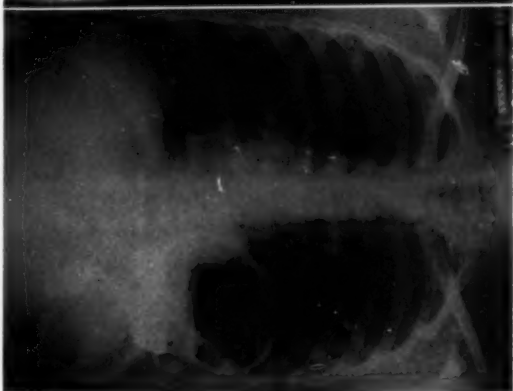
Pre-operative AP and lateral chest x-ray film showing left lower lobe consolidation. FIGURE 2: Barium study revealing diaphragmatic hernia and an unsuspected pre-operative aberrant lobe.
